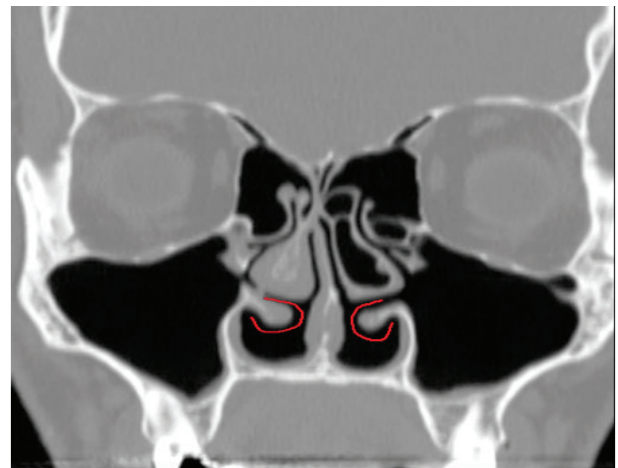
Measurements of ITV in a 32 years old male patient with empty nose syndrome of both nasal cavity. The ITV on the coronal CT image was quantitatively calculated by summing areas that were manually traced on every imaging slice and multiplied by the slice thickness
